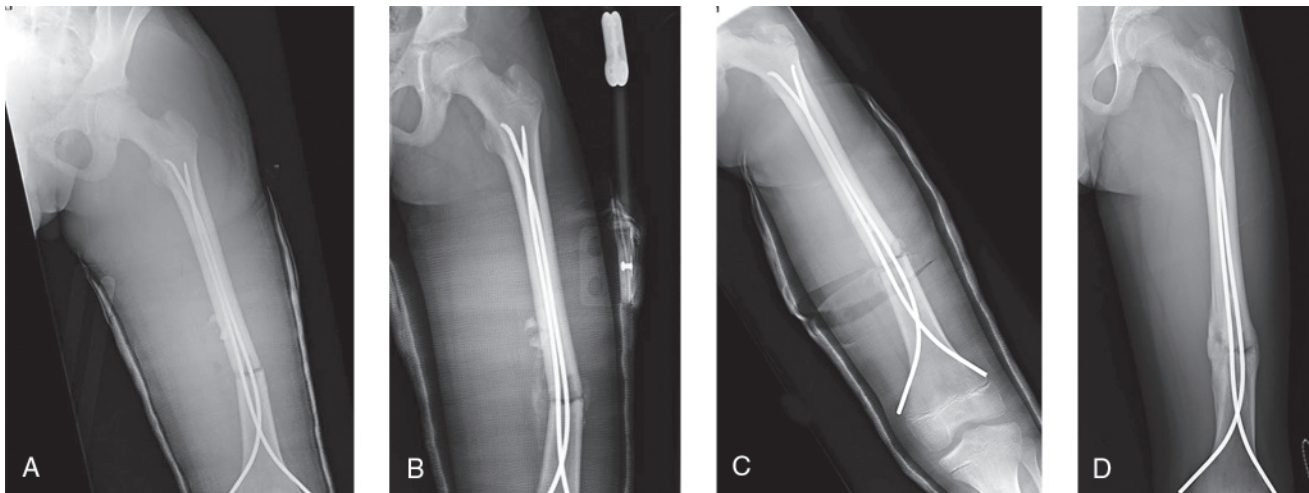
A, Immediate postoperative radiograph of a transverse femoral fracture in a 12-year-old girl treated with flexible nail fixation. B, Radiograph taken at the 1-week follow-up shows 15° of angulation in varus. C, Radiograph of the fracture after the cast was wedged in the clinic. D, Radiograph of the fracture at the 3-month follow-up.
